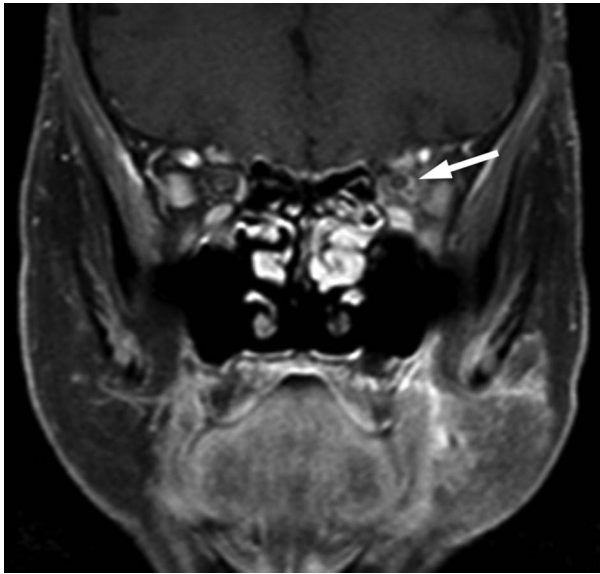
MRI on presentation demonstrated increased enhancement of the left cavernous sinus region, with subsequent 6-month follow-up demonstrating residual mucosal thickening of the left sphenoid (arrow).
